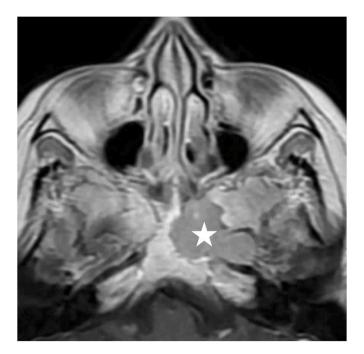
Contrast-enhanced axial T1 MRI. The left cavernous sinus lobulated enhancing lesion extends laterally into left sphenoid wing and medially across midline.
